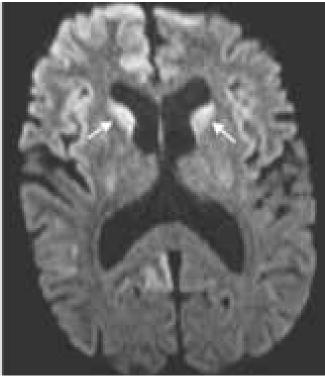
MRI Brain Axial diffusion-weighted slices show restricted diffusion within the cortical ribbon and caudate heads.
